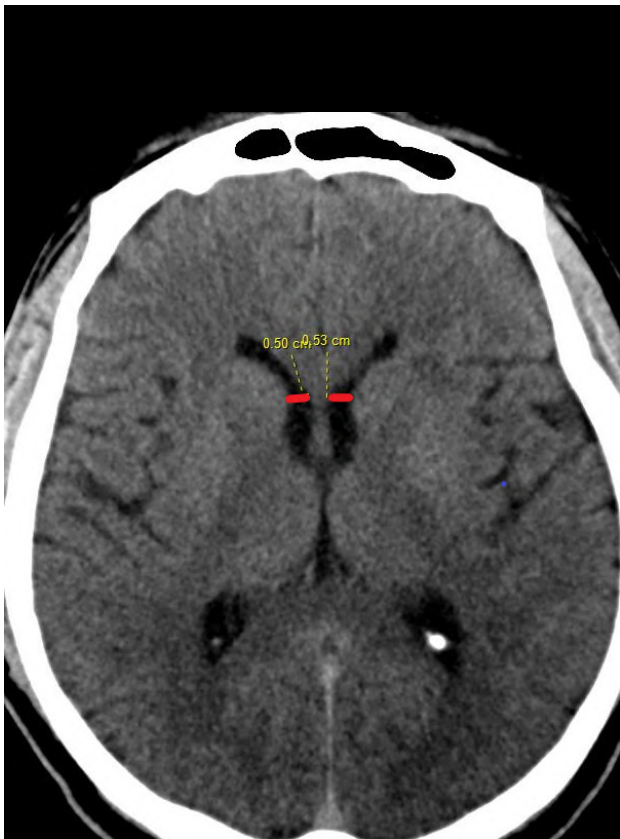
Axial CT sections of the brain showing measurement of the maximum frontal horn width.
